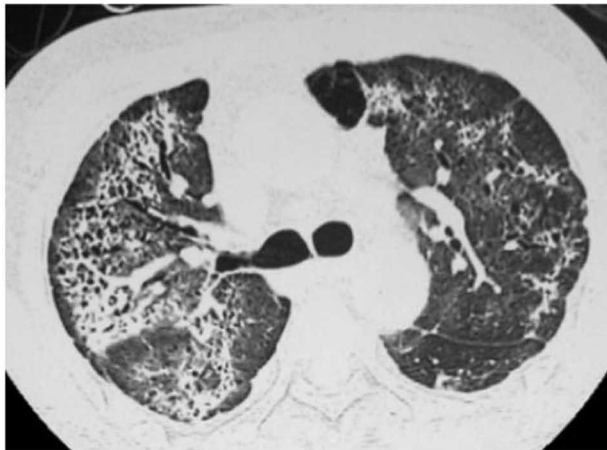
Top, A: HRCT scan of the lung area in a 60-year-old woman with SARS showing interstitial thickening and ground-glass opacification. Bottom, B: The second CT scan shows improvement of lung abnormalities. The two HRCT images are not from the same anatomic level and are of different attenuation.
